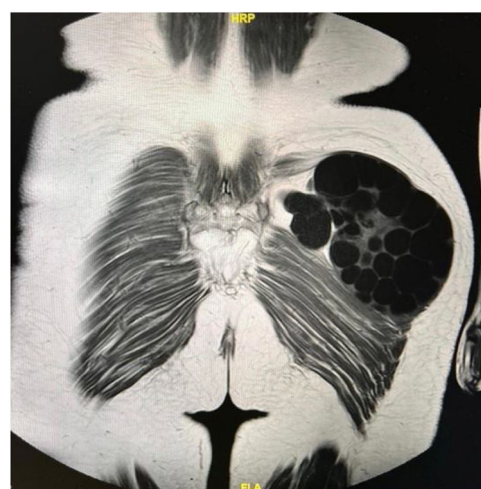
CT of the thorax, abdomen and pelvis. Multilocular lesion in the buttock.
